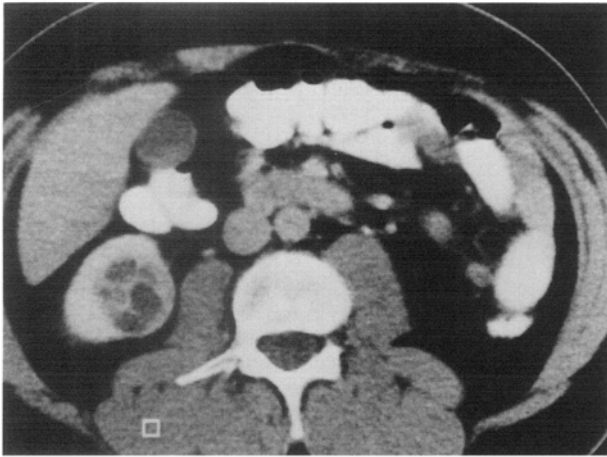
Multiloculated renal cell carcinoma (category III). The patient was a 47-year-old man. Enhanced CT scan shows a multiloculated renal mass. Nephrectomy confirmed that the mass was a renal cell carcinoma.
